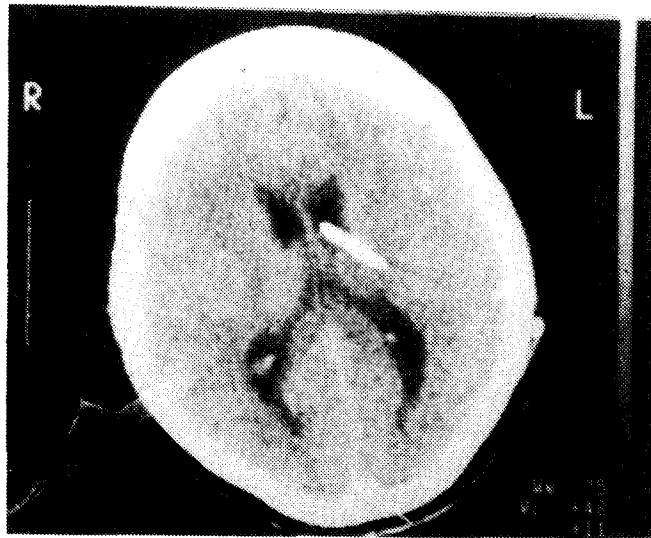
Post shunt CT showing change in the degree of hydrocephalus to normal ventricular size index (same patient in Fig. 5a).
